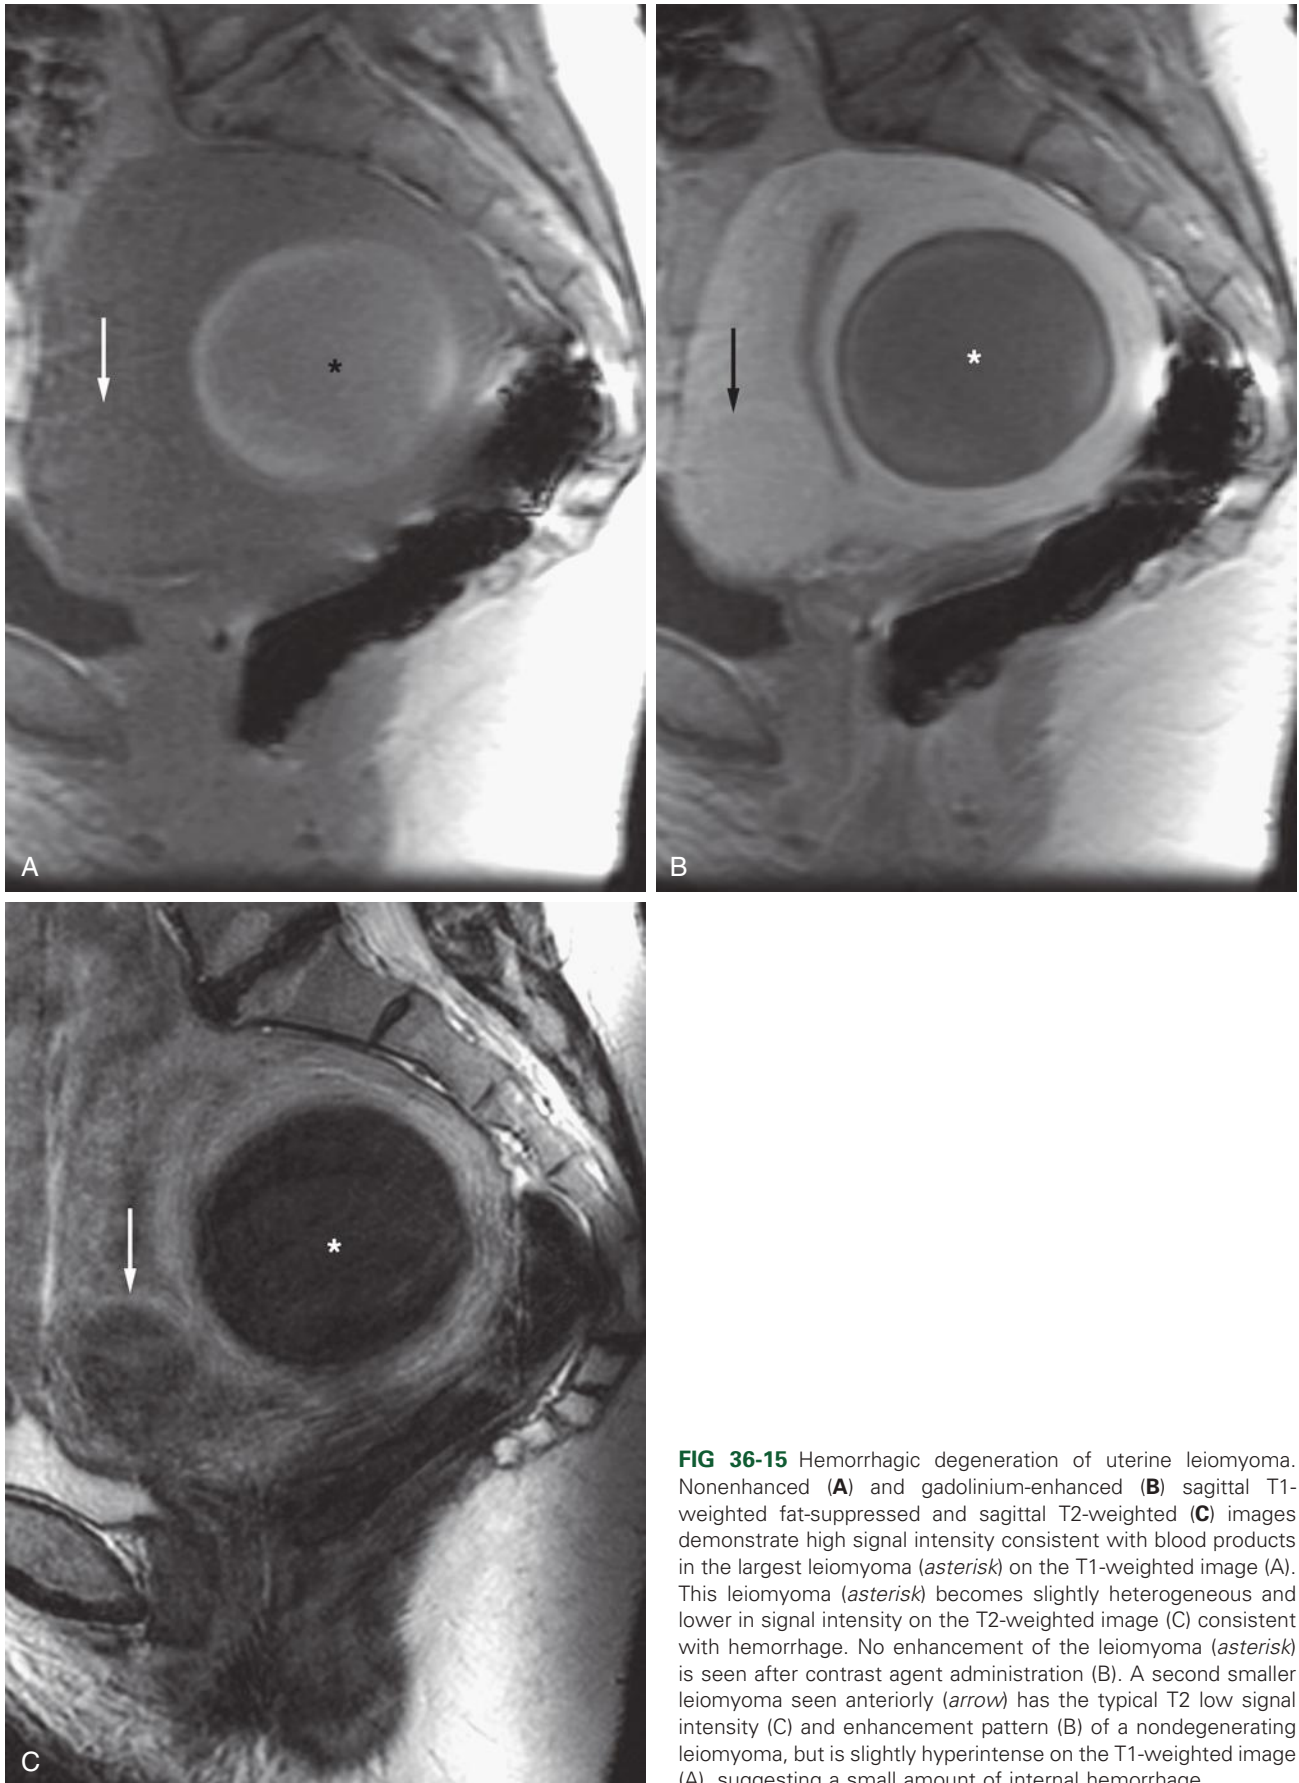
Hemorrhagic degeneration of uterine leiomyoma. Nonenhanced (A) and gadolinium-enhanced (B) sagittal T1-weighted fat-suppressed and sagittal T2-weighted (C) images demonstrate high signal intensity consistent with blood products in the largest leiomyoma (*asterisk*) on the T1-weighted image (A). This leiomyoma (*asterisk*) becomes slightly heterogeneous and lower in signal intensity on the T2-weighted image (C) consistent with hemorrhage. No enhancement of the leiomyoma (*asterisk*) is seen after contrast agent administration (B). A second smaller leiomyoma seen anteriorly (*arrow*) has the typical T2 low signal intensity (C) and enhancement pattern (B) of a nondegenerating leiomyoma, but is slightly hyperintense on the T1-weighted image (A), suggesting a small amount of internal hemorrhage.
